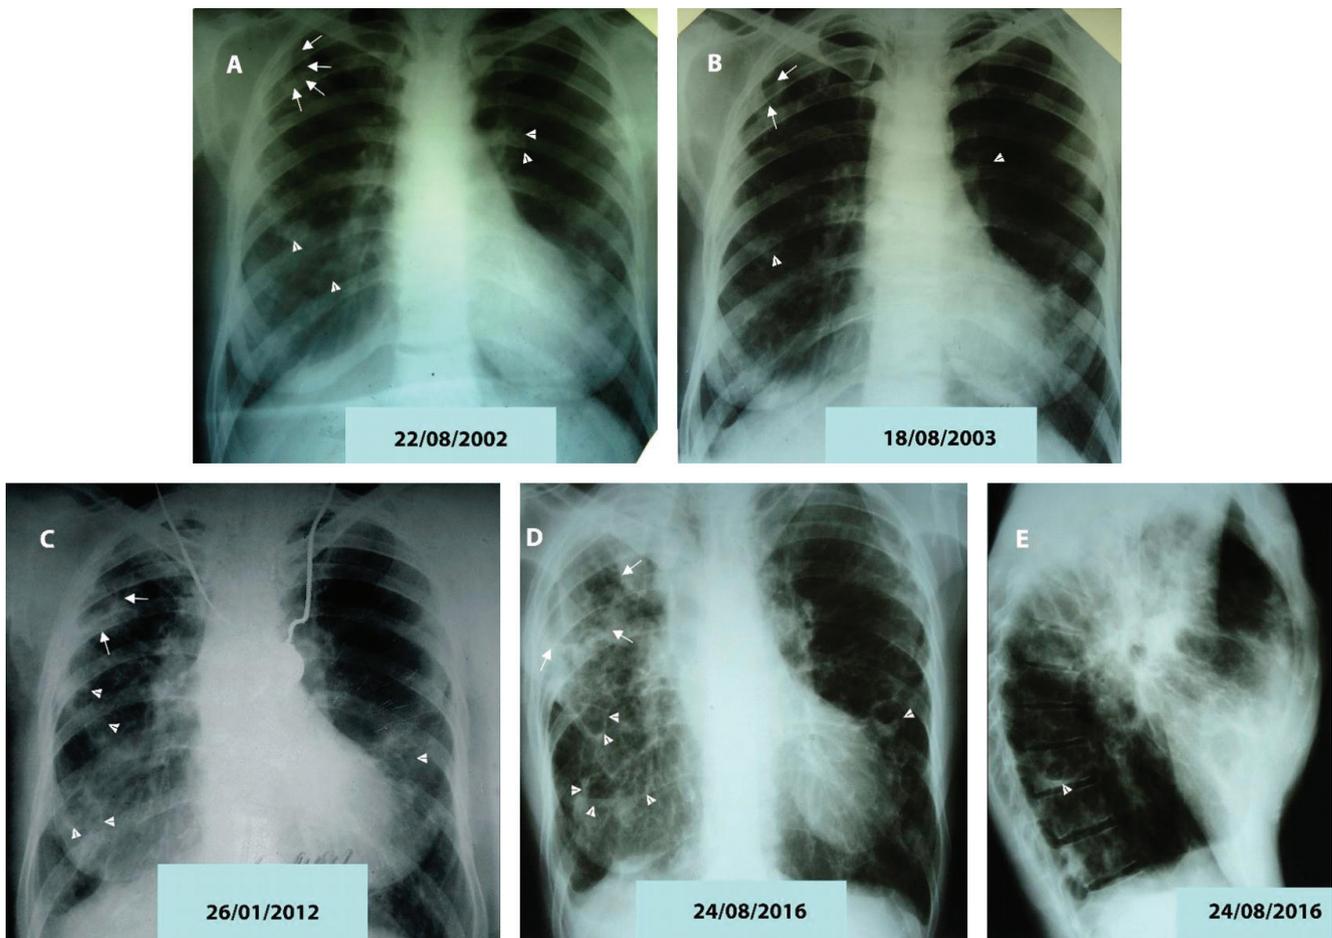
(A) Chest radiograph during the episode of TB relapse (22 August 2002) showing a cavitory lesion in the upper right lobe (arrows) and multiple nodular opacities (suggestive of mucoid bronchial impaction), circular opacities (arrowheads) and the tram-track appearance of bronchial walls, with paired parallel linear opacities radiating from the hilum of both lungs, more prominent in the right inferior area. Note "rosette" images in the left perihilar area (arrowheads). The right hemidiaphragm, costophrenic angle and cardiac silhouette are obscured due to fibrotic lesions. (B) Chest radiograph after 1 year of treatment for PTB showing persistence of previous pulmonary lesions and a small improvement of peribronchial cuffing. (C) A 9 years later chest radiograph (26 January 2012) reveals extensive fibrosis, reduced size of the right lung and progression of the bronchiectasis (arrowheads) with upward hilar traction. A possible fungus ball with the air-crescent sign could be supposed inside the cavitory lesion (arrows). (D, E) 12 years later (24 August 2016), frontal and lateral view of chest radiography showing reduced upper lobe volume with an important thickening of the pleura and a single lung cavity with thick walls and completely destroyed right upper lobe. Progression of varicose and cystic bronchiectasis (some of them with air-fluid level – arrowheads) in both lungs; right side traction and dilatation of the trachea were identified. Associated signs of hyperinflation could be seen; there are marked flattening of the hemidiaphragms (more evident on the lateral view) and widening of the retrosternal clear space.
